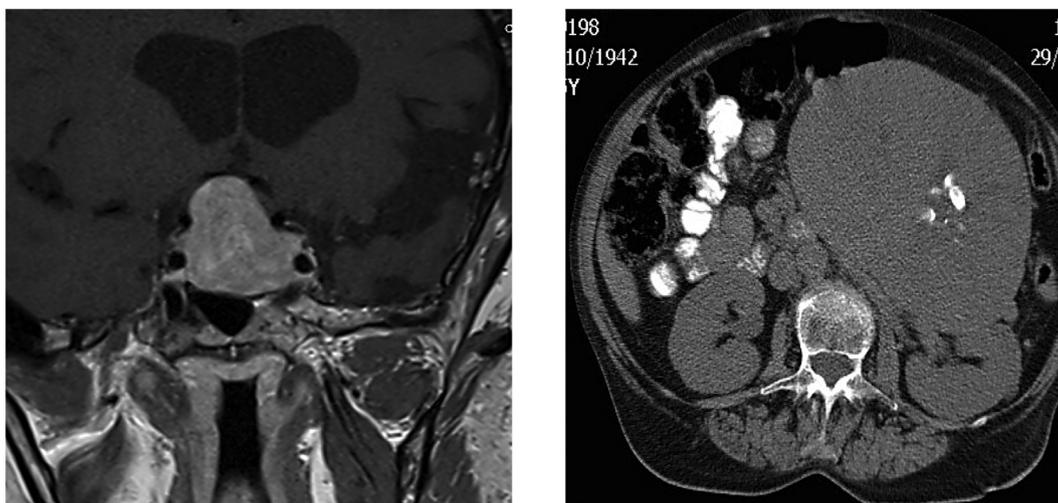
A (Case 1): Coronal T1 weighted gadolinium-enhanced MRI corresponding with a non-functioning pituitary adenoma. B (Case 4): CT displaying a left pheochromocytoma.
